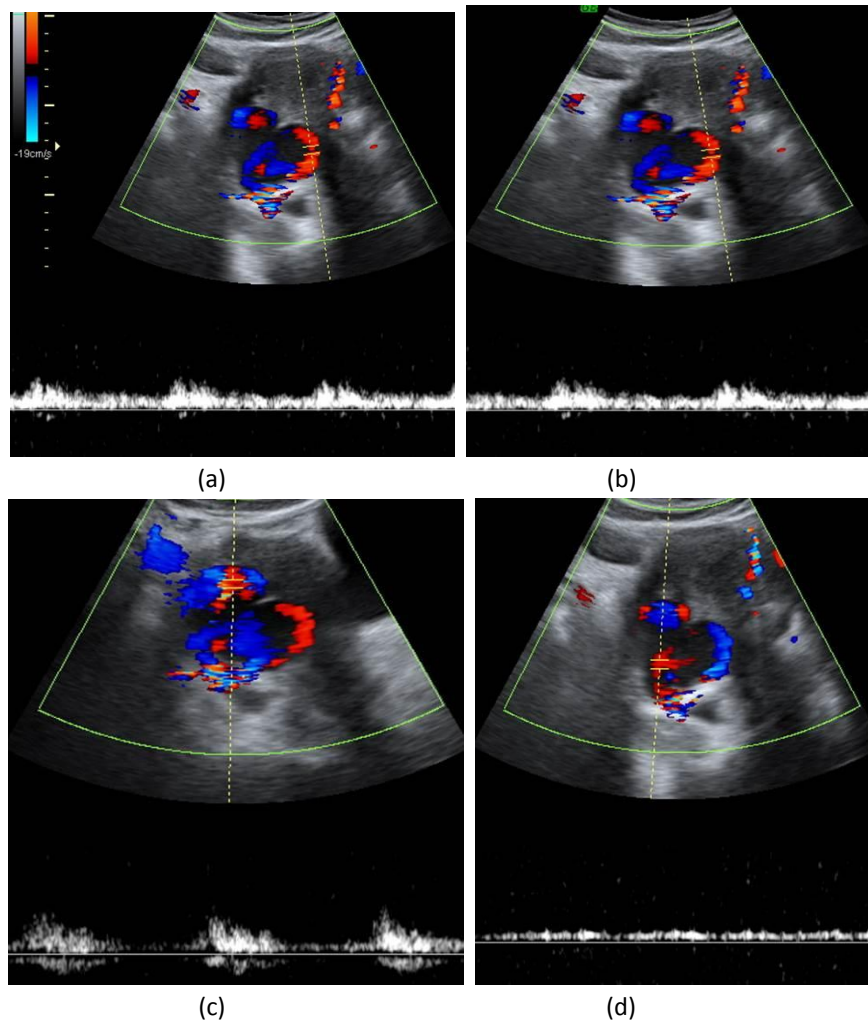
Pulsed Doppler spectral analysis of intralésional arterial flow demonstrates high-velocity flow with a low resistive index, and spectral analysis of intralésional venous flow shows high peak systolic velocities consistent with an arterial flow pattern.
